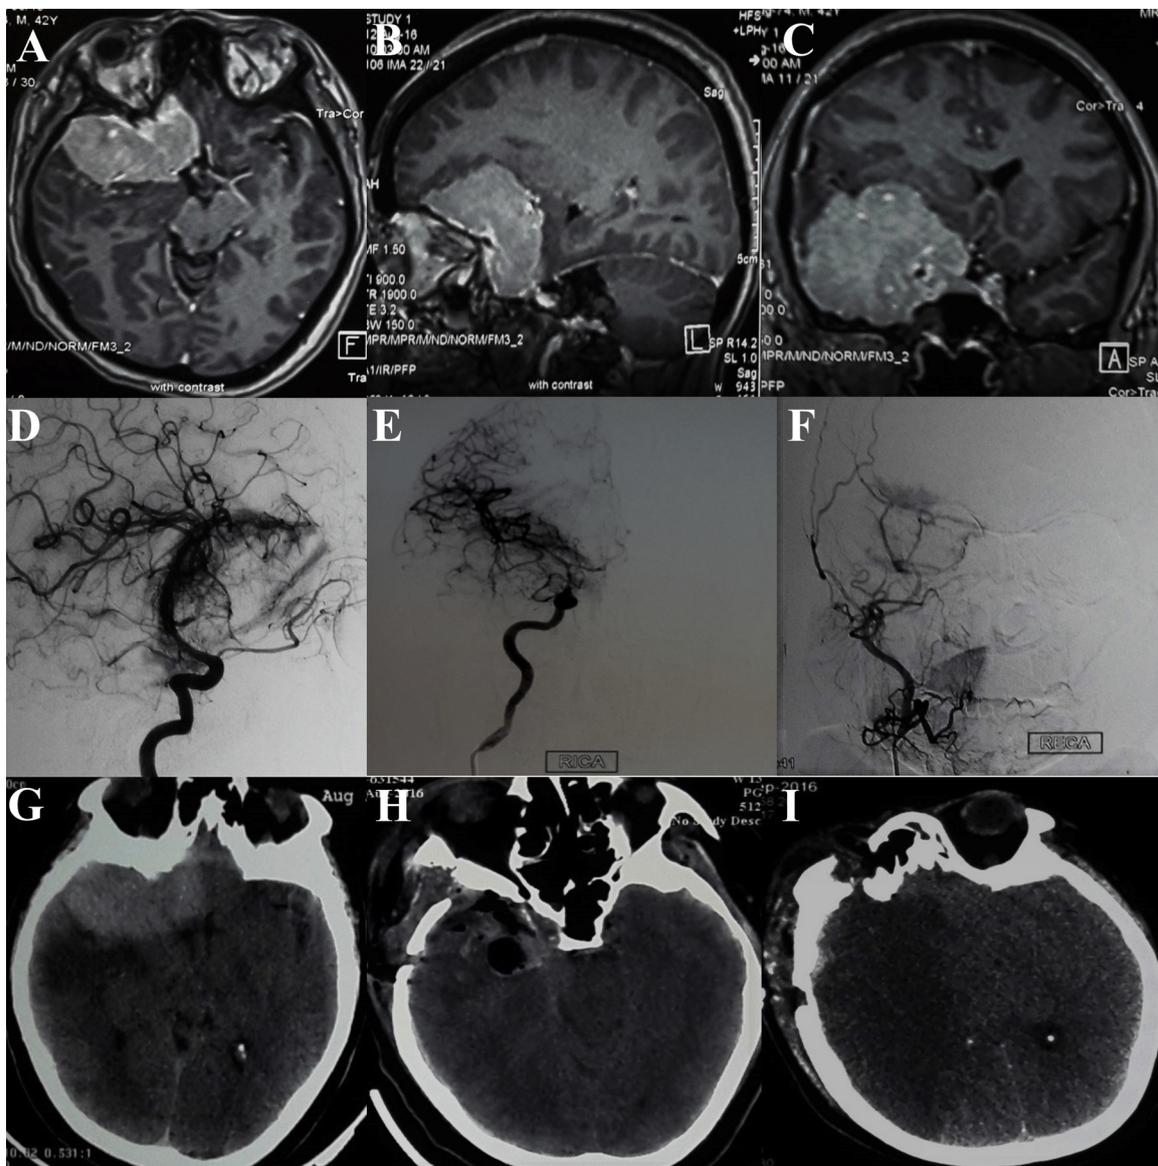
A–C) Preoperative Contrast MRI in axial, coronal and sagittal planes demonstrating clinoid meningioma encasing ICA bifurcation and origin of both A1 and M1 origin D & E) DSA, showing blush from supraclinoid ICA. ICA, M1 and A1 are encased, stretched and narrowed F) DSA with ECA injection showing minimal blush from ECA G) Preoperative NCCT demonstrating hyperdense lesion H) immediate postoperative NCCT showing GTR I) Postoperative scan on day 2 demonstrating MCA infarct on the ipsilateral side.
